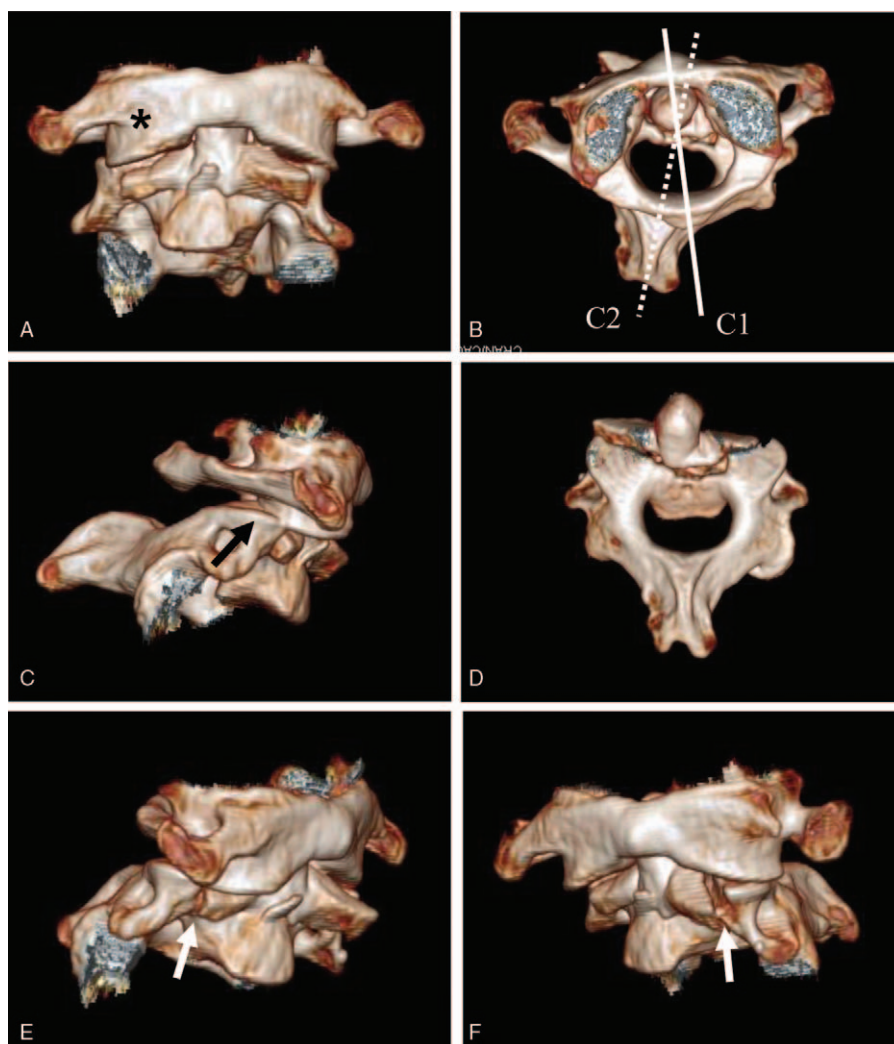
Three-dimensional reconstructed CT scans confirmed type 2 traumatic C1–2 rotatory subluxation that was established based on Fielding and Hawkins classification (asterisk and dark arrow) (A, B, and C) and revealed a type 3 dens fracture (Anderson and D’Alonzo classification) (D) and bilateral articular facet fractures of C2 (white arrows) (E and F). CT=computed tomography.
